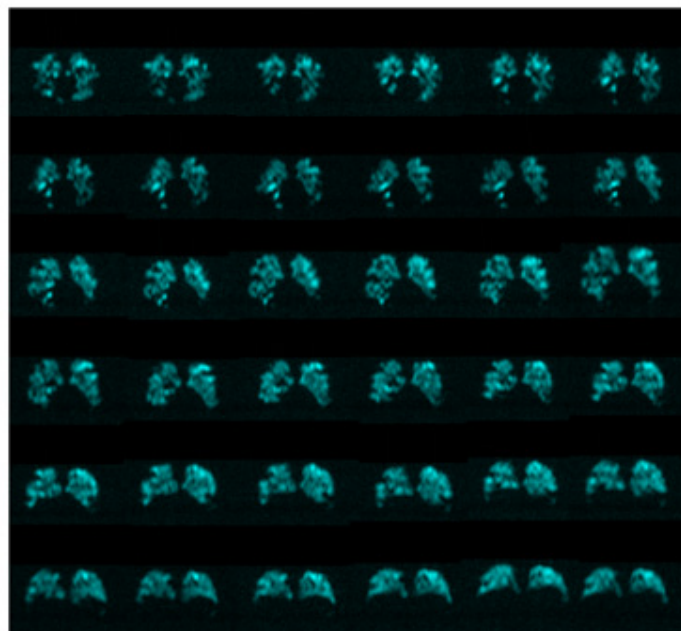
Representative axial 80-slice ^{129}Xe MRI images.
